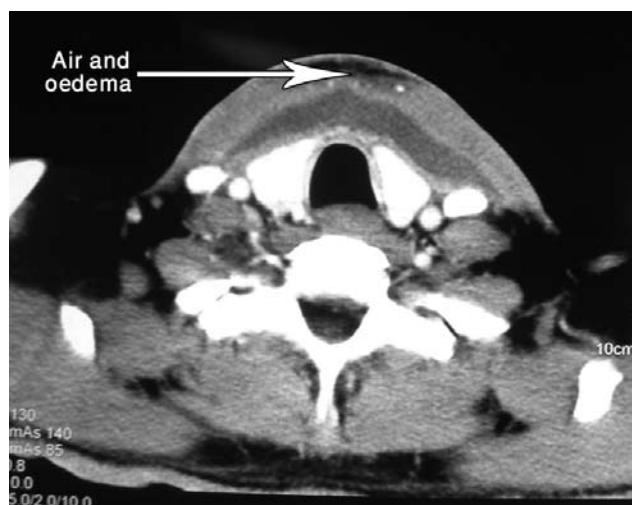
Axial neck post-contrast CT shows subcutaneous air and the retro-sternal space soft tissue edema.
